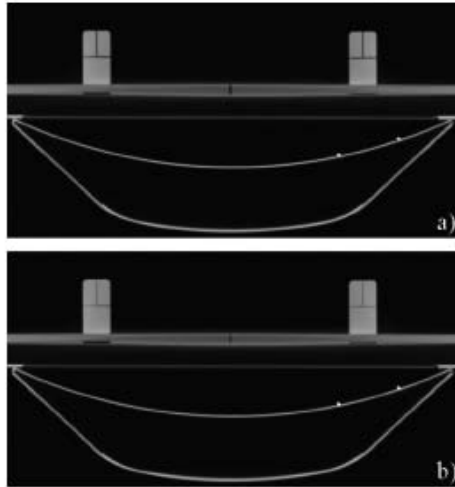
A CT image of a laser alignment QC test device: (a) lasers aligned with an imaging plane; (b) centre of a test device offset by 1 mm from the imaging plane. Courtesy: S. Mutic [7].
